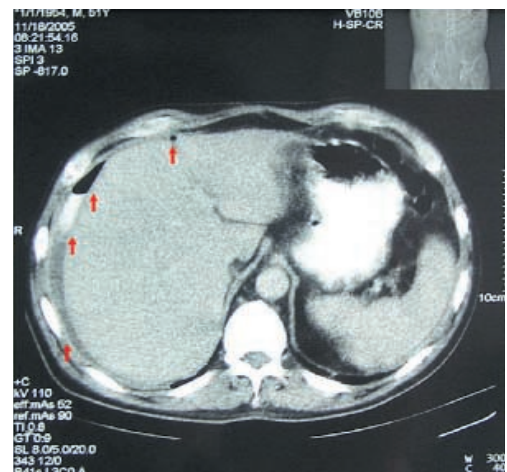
Air and contrast agent on CT scan after gastrointestinal perforation.
